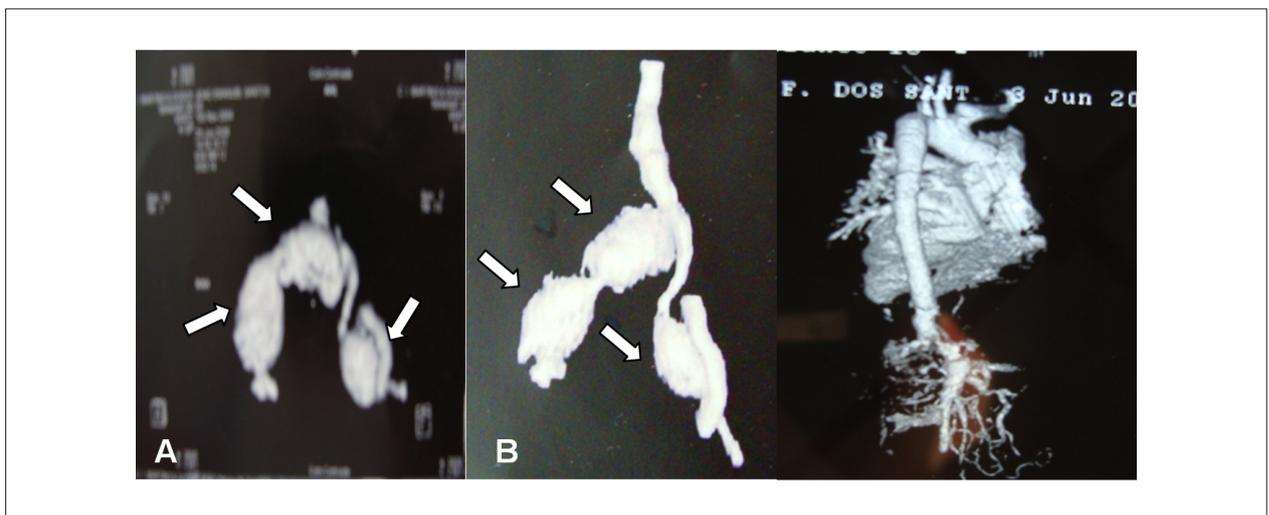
CT angiography showing three large aneurysms in the iliac arteries bilaterally (A) and (B) study of the aortic arch and the innominate artery with no complications.
